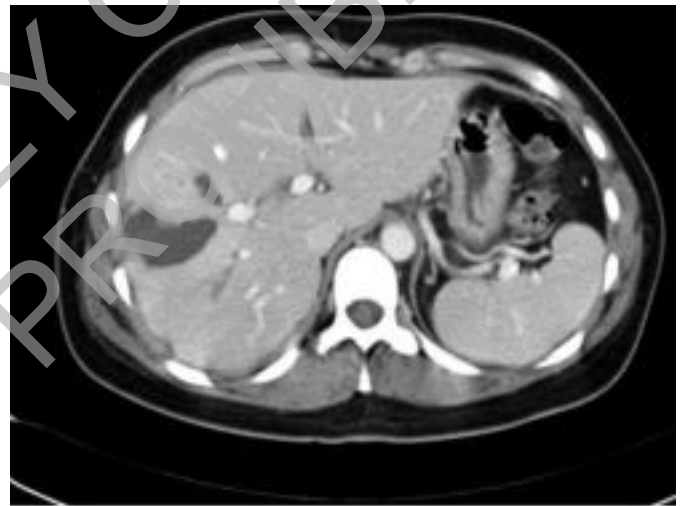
CT scan (seven days after trauma) showing volumetric reduction of the liver lacerations, which appear to be more hypodense in relation to phenomena of parenchymal necrosis.
